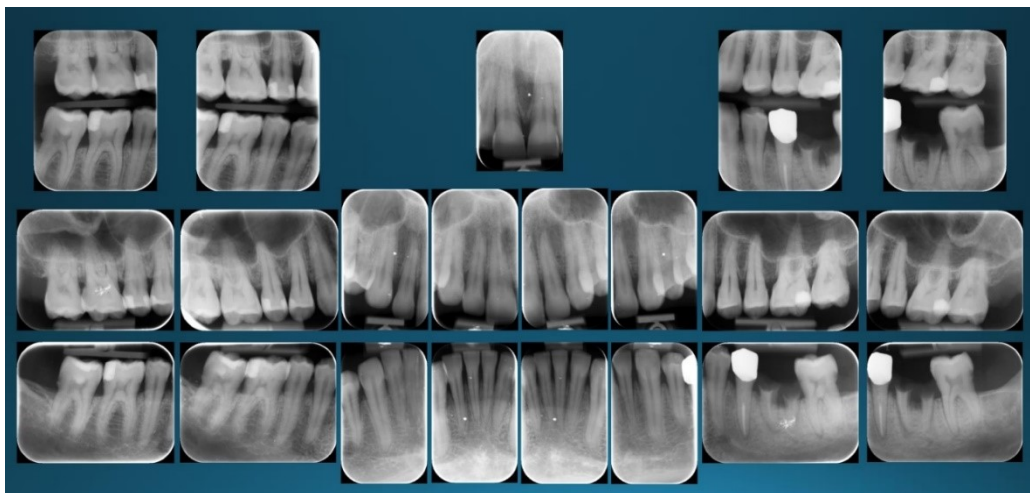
Retroalveolar serial radiographs
